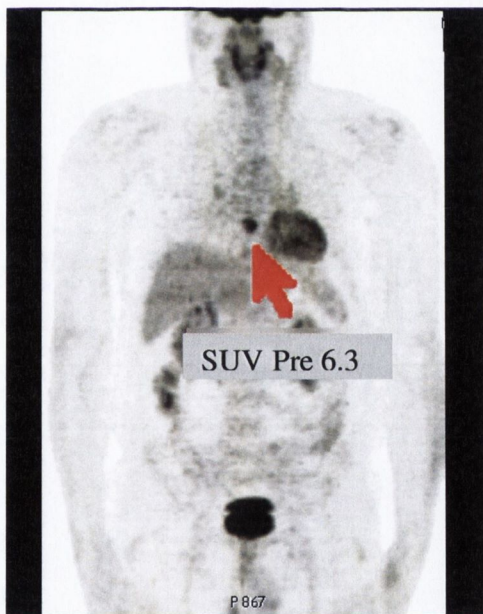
iii: Responder (patient 1) demonstrating reduction in SUV from before (PRE) to during (Intra) chemoradiation
